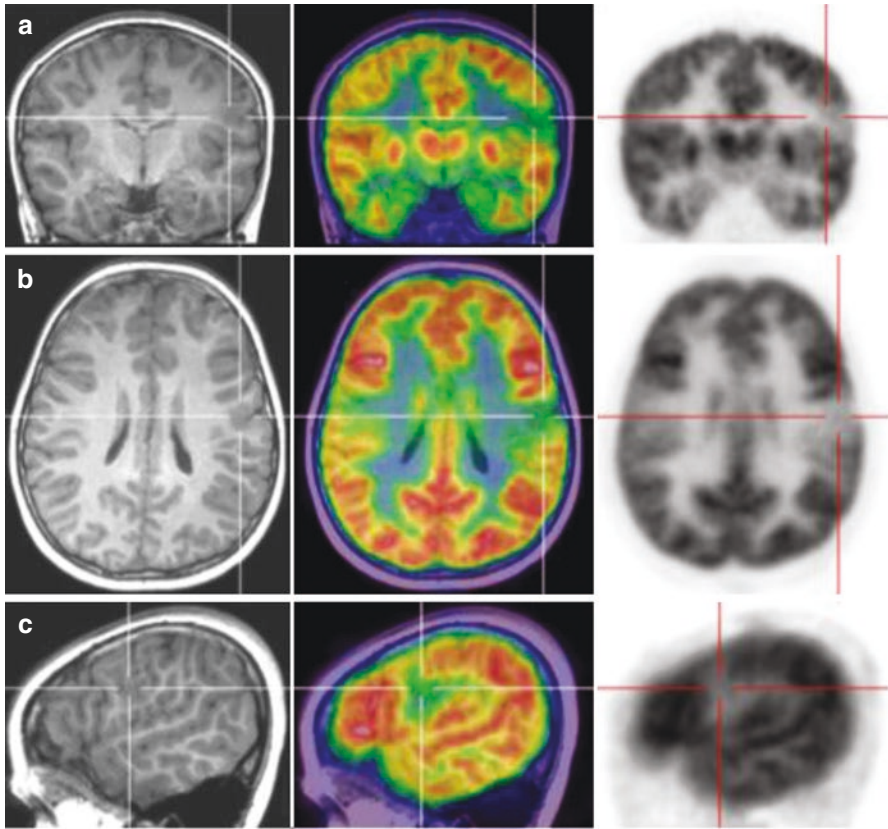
Extratemporal lobe epilepsy. (a, coronal view; b, axial view; c, sagittal view of MRI T1-weighted, PET/MR fusion, and FDG-PET). Left frontal posterolateral cortical dysplasia seen as a focal thickening of the cortex (white axes in the first column). PET/MR fusion and FDG-PET showed a left frontal posterolateral hypometabolic area, larger than the morphological abnormality (white and red axes, in the second and third columns, respectively)
